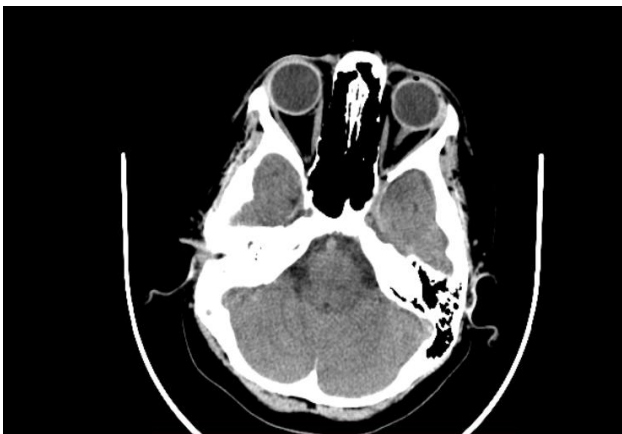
Head CT scan without contrast enhancement of loss of pneumatisation in right mastoid.
